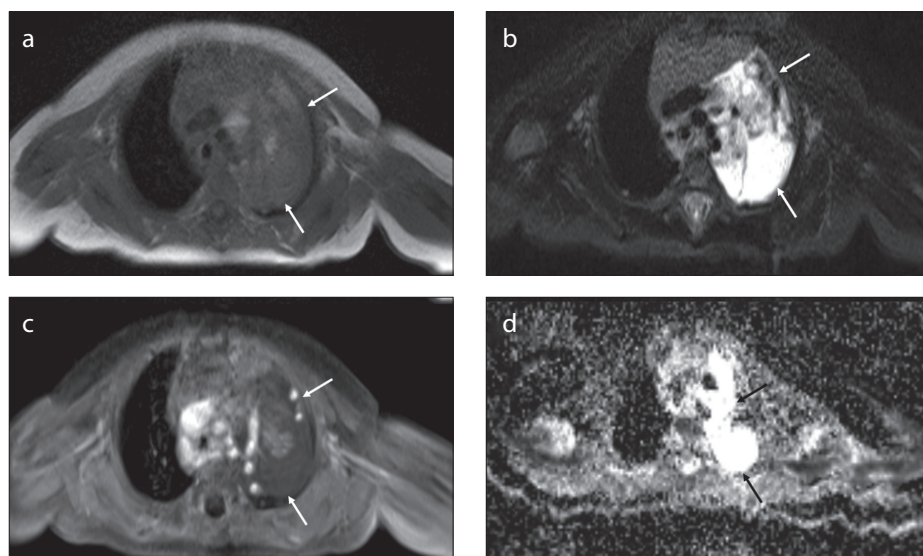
a-d. An 8-year-old male with pathologically confirmed cavernous hemangioma in the left upper lobe. Axial T1-weighted (a) and T2-weighted (b) images reveal the cavernous hemangioma lesion (white arrows). Axial postcontrast-enhanced T1-weighted image (c) reveals peripheral and internal contrast enhancement in the cavernous hemangioma lesion (white arrows). Axial diffusion-weighted (ADC map) image (d) reveals no diffusion restriction (white arrows).
